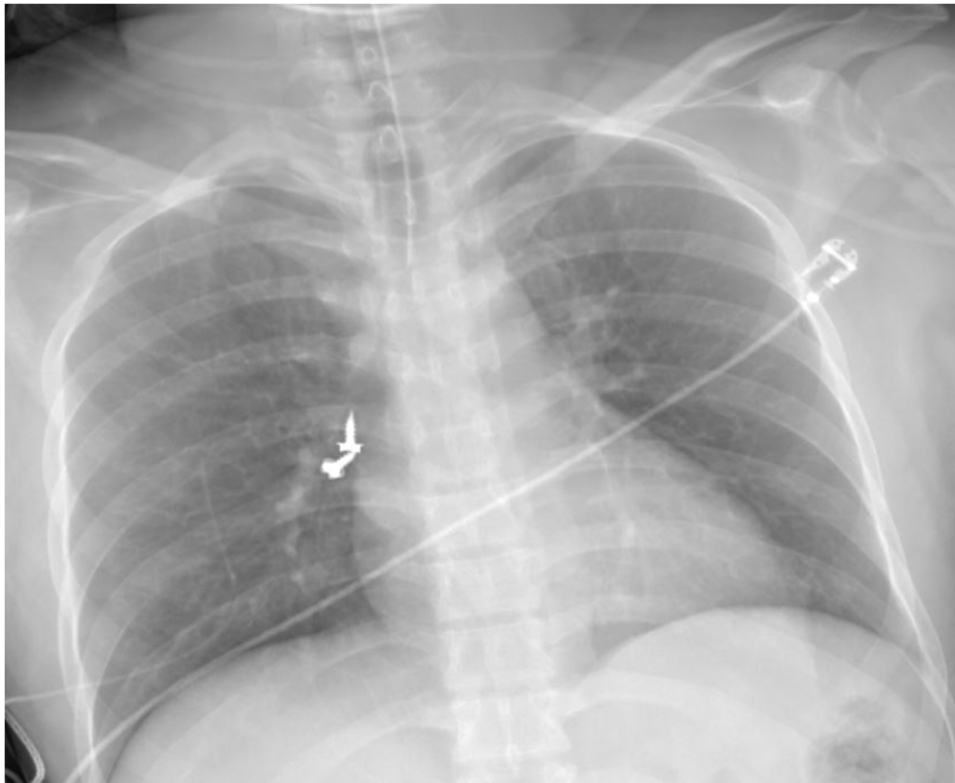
Admission X-ray significant for metallic foreign bodies in the airway.
